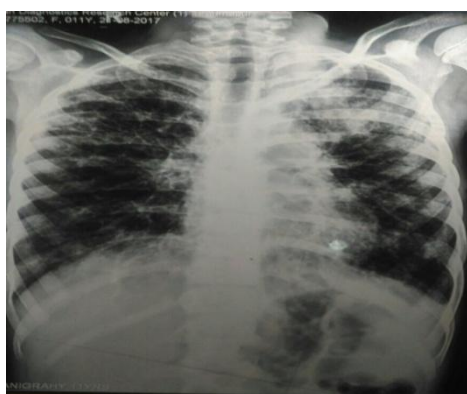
chest radiography showing cystic and reticular appearance in all zones and air space consolidation in upper zone
